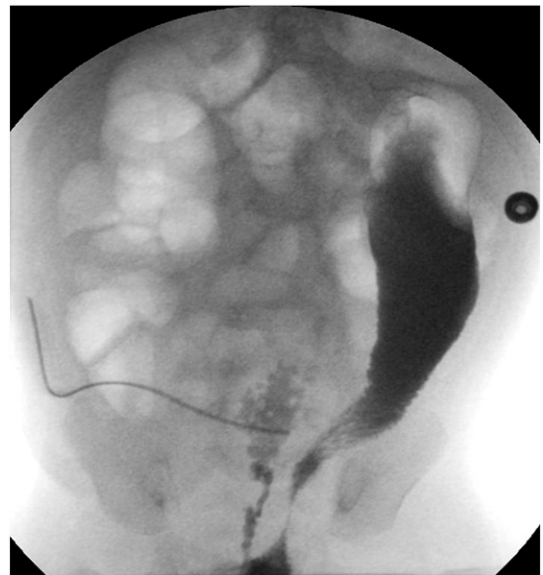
X-ray showing an anastomotic leak and enterocutaneous fistula after a TERPT (patient 5).
